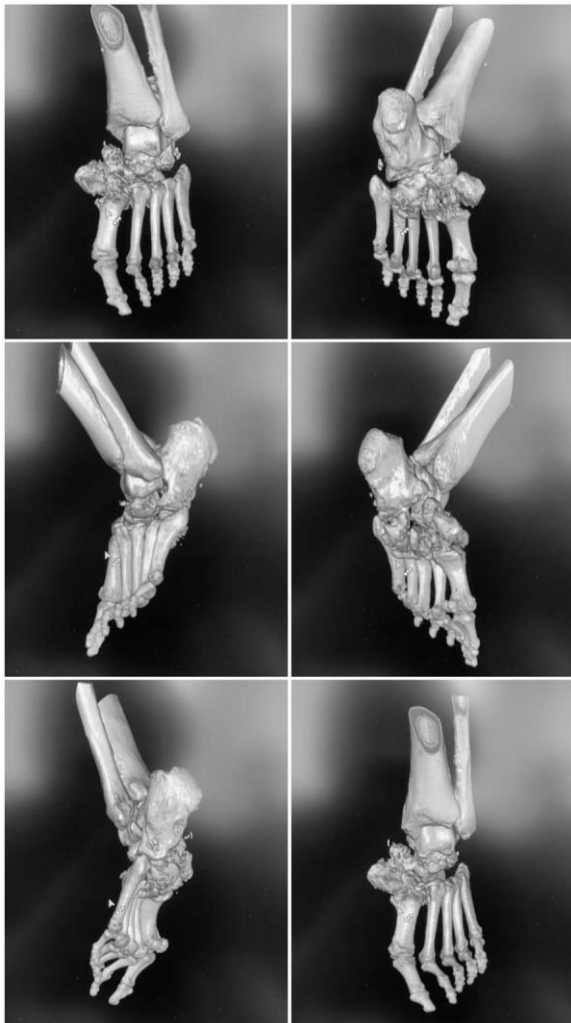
CT-Scan bone-view shown no abnormalities on bones and soft tissue.
